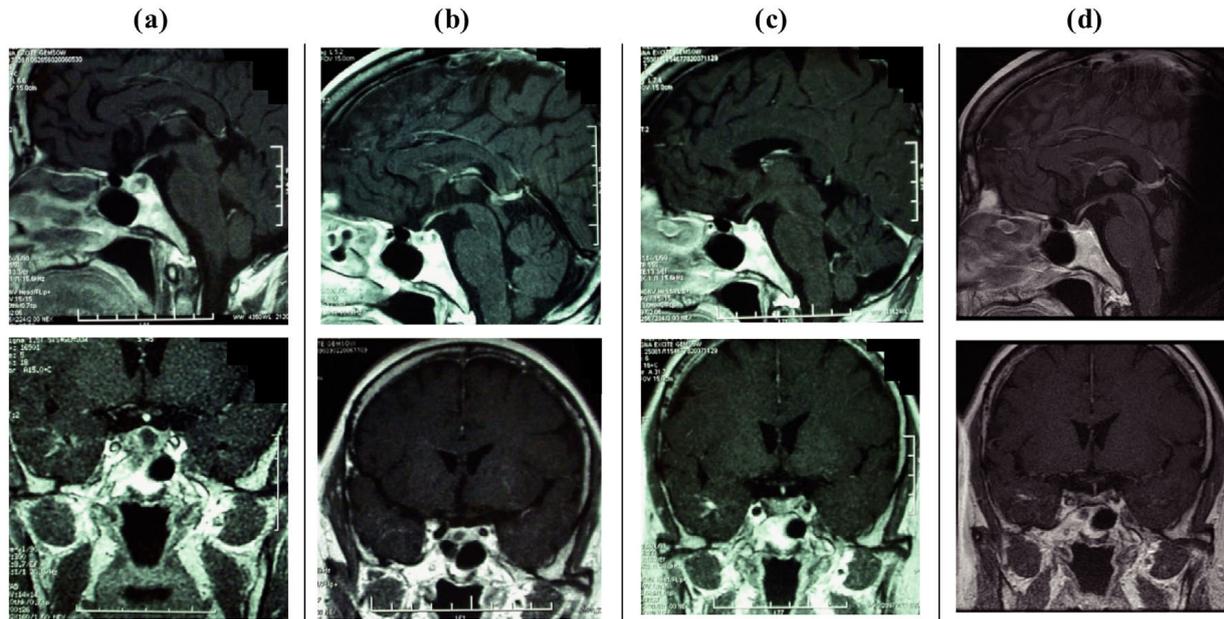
Time course of changes in MRI findings after manifestation of disease. Top: Sagittal T1-weighted image with gadolinium contrast; Bottom: Coronal T1-weighted image with gadolinium contrast. (a) Four months after onset of central diabetes insipidus. (b) Twelve months after onset. (c) Two years after onset. (d) Three years after onset.
